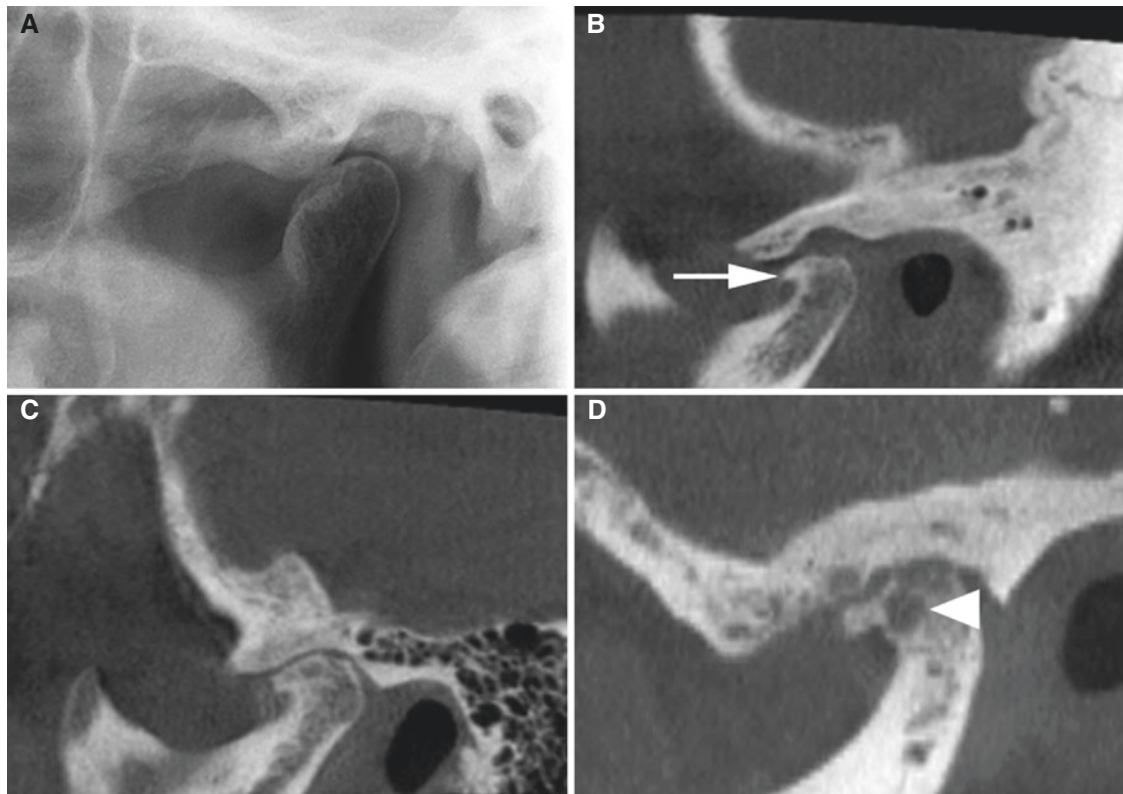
Osteoarthritis; 71-year-old female with hand osteoarthritis (participant in research project) without TMJ symptoms. (A) Panoramic view suggests radiopacity in the left condyle. (B) Oblique sagittal CBCT image of same patient shows condylar osteophyte/sclerosis (arrow). (C) Oblique sagittal CBCT image of another patient shows
